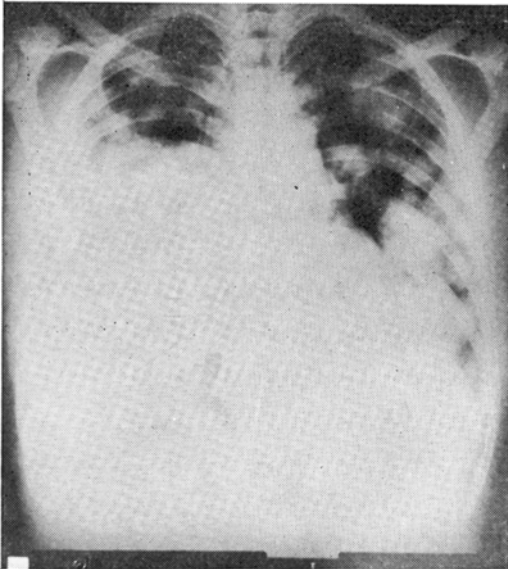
Chest X-ray showing a large tumour mass in the right chest cavity and multiple fluffy tumour nodules in the left chest.
